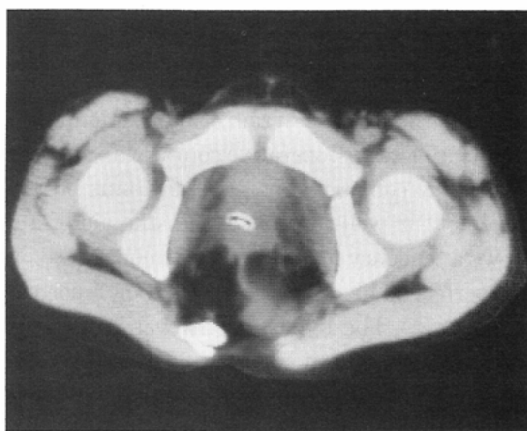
Case 1. CT. Lower level than Fig. 5. There are coccygeal deviation and the fistula between the mass and rectum.
